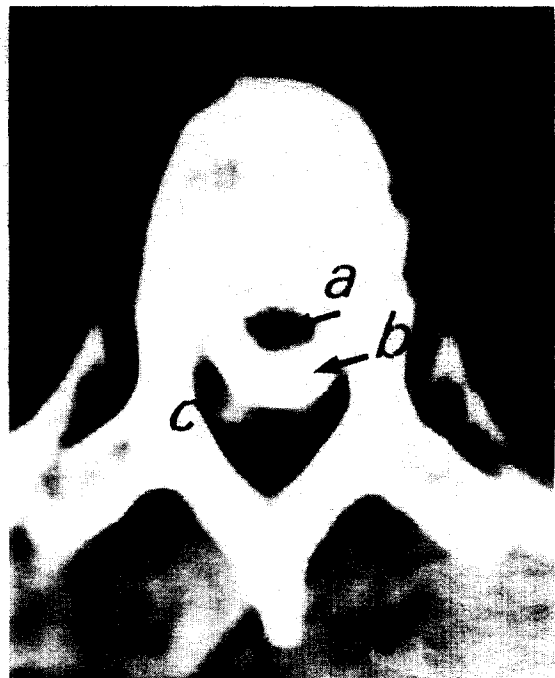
CT scan T6 -- (a) spinal cord, (b) intrathecal amipaque contrast, (c) dorsally placed extradural mass (haematoma).
